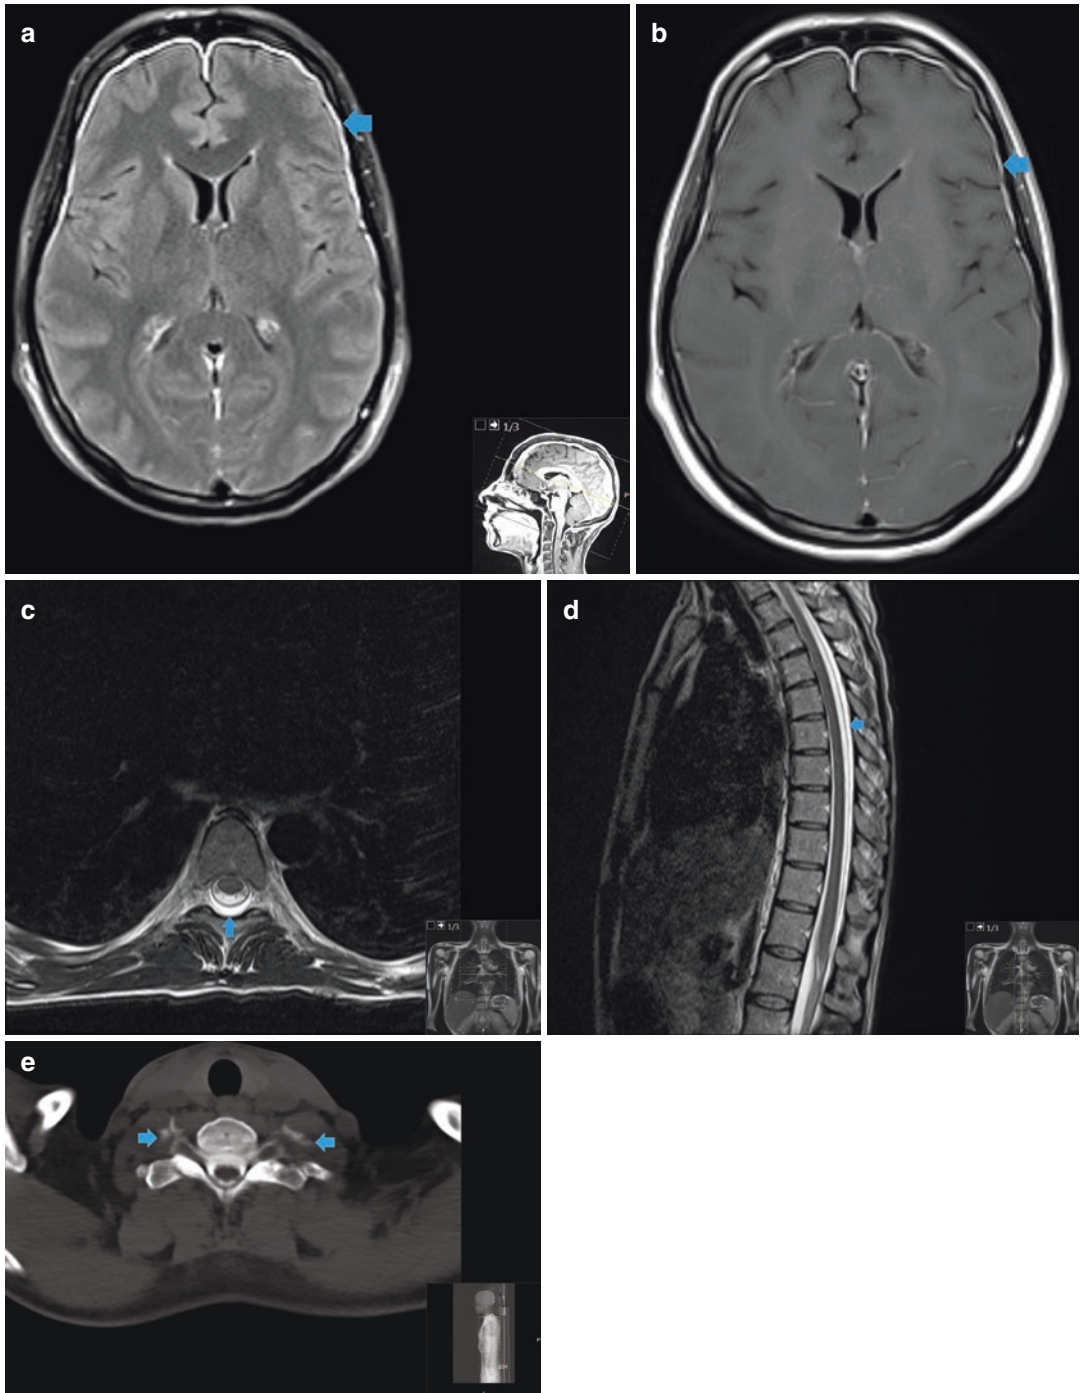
CSF leak. Figures 9.15a and b are axial FLAIR and postcontrast MR images of the brain, respectively, showing thin diffuse subdural collections and diffuse dural thickening and enhancement (arrows), in keeping with spontaneous intracranial hypotension. Figures 9.15c and d are axial and sagittal T2-weighted
